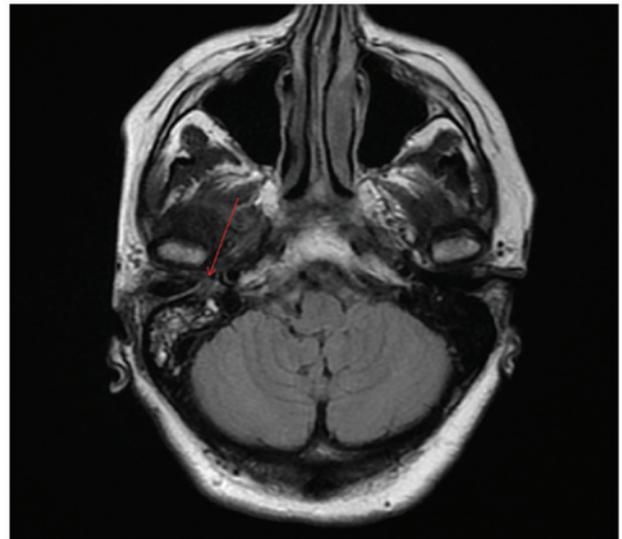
Pre-operative T2 brain magnetic resonance imaging performed in January 2010, showing a hyperintense tissue mass occupying the tympanic cavity. The arrow indicates the presence of the hyperintense mass.
